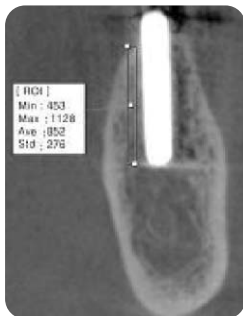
Real example of calculating the CT number.
